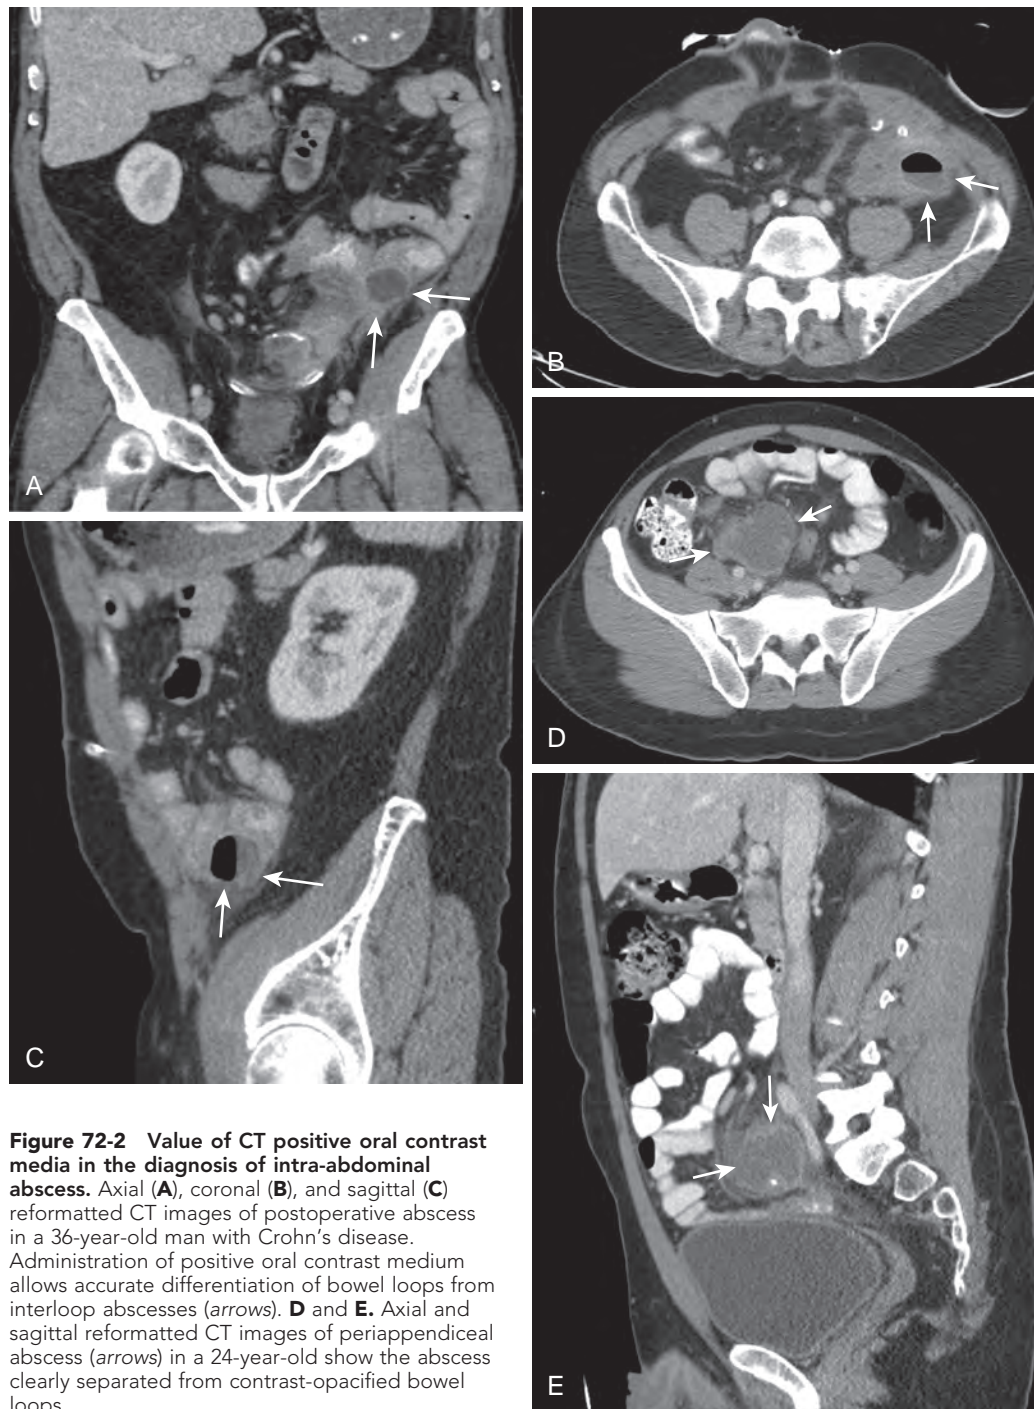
Value of CT positive oral contrast media in the diagnosis of intra-abdominal abscess. Axial (A), coronal (B), and sagittal (C) reformatted CT images of postoperative abscess in a 36-year-old man with Crohn's disease. Administration of positive oral contrast medium allows accurate differentiation of bowel loops from interloop abscesses (arrows). D and E. Axial and sagittal reformatted CT images of periappendiceal abscess (arrows) in a 24-year-old show the abscess clearly separated from contrast-opacified bowel loops.
